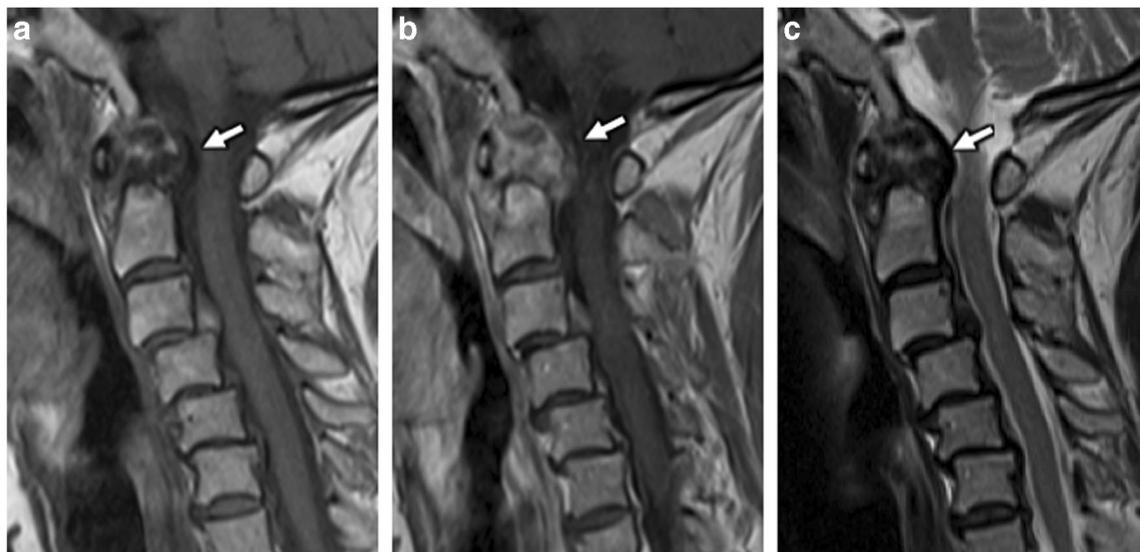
a A 64-year-old woman with 21-year-long history of rheumatoid arthritis with mixed signal intensity (“hypovascular”) pseudotumor. Sagittal T1-weighted pre-contrast demonstrates T1 hypointense tissue around the odontoid dens. b Sagittal T1-weighted image demonstrates
